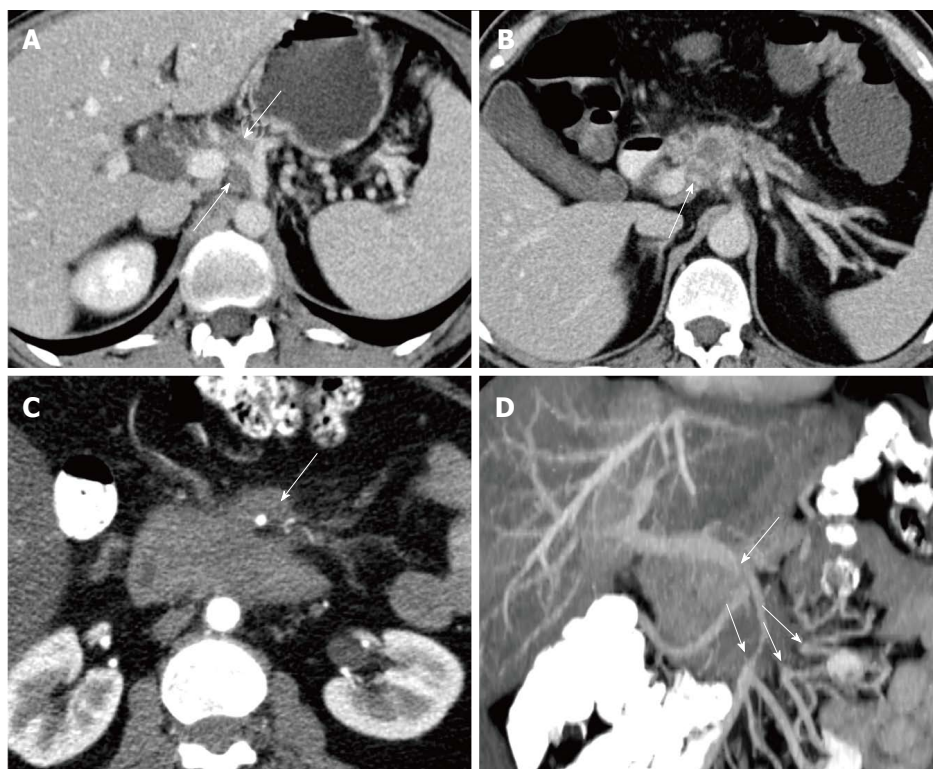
Examples of resectability assessment in untreated pancreatic ductal adenocarcinoma by means of computed tomography. A: Unresectability due to encasement of the common hepatic artery reaching to the celiac trunc (arrows); B: Borderline resectability with infiltration of the portal vein and one-sided contact to the common hepatic artery without extension to the celiac trunc. Neoadjuvant treatment and/or pancreatic left resection with *en-bloc* resection of the celiac trunc (after embolization) can be considered; C: Unresectability due to encasement of the superior mesenteric artery by more than 180°; D: Infiltration of the superior mesenteric vein and venous confluence with stenosis and multiple separated mesenteric venous branches unsuitable for surgical reconstruction.
